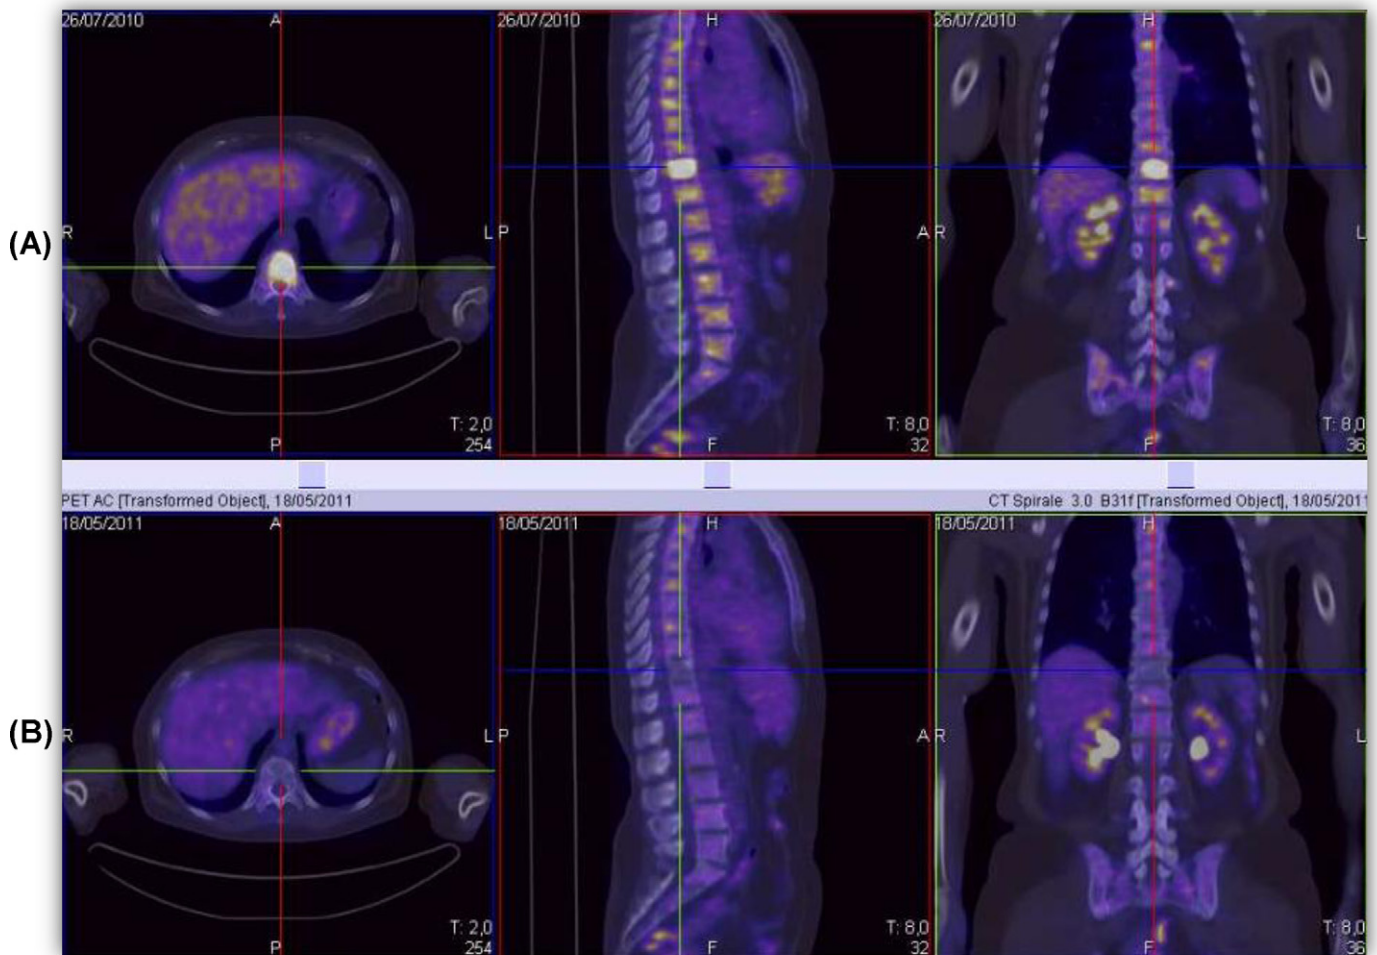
An example of a patient with diffuse bone marrow involvement at PET/CT before (A) and after treatment (B).
